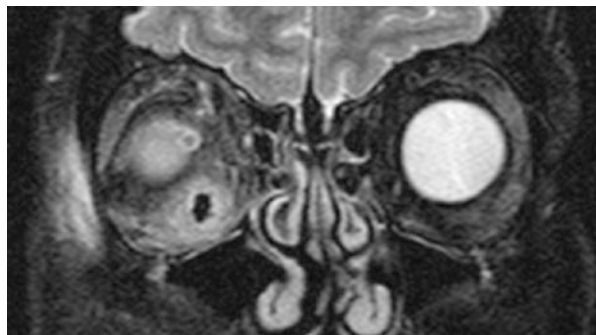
Coronal MRI scan of the orbits showing orbital cellulitis on the right side associated with a retained wood fragment foreign body sustained after patient was struck with a tree branch
